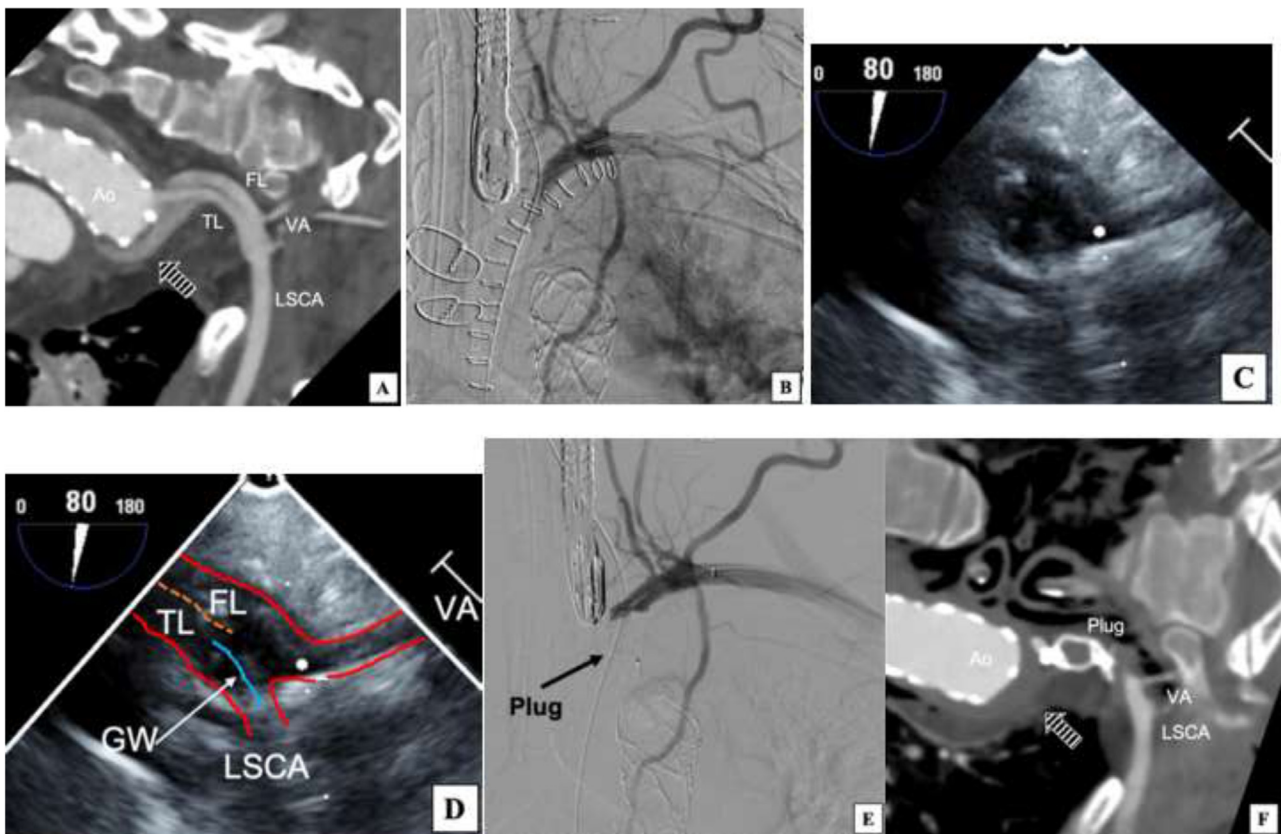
(A) Postoperative contrast-enhanced computed tomography showed retrograde blood flow around the frozen elephant trunk (striped arrow) from the false lumen of the left subclavian artery. The communication between the true and false lumens was at the level of the origin of the vertebral artery. (B) Left brachial artery angiography. (C) and (D) Transesophageal echocardiogram showed the left subclavian artery and vertebral artery. The left subclavian artery contained a true and false lumen. The entry of the false lumen was at the vertebral artery origin. The red lines denote vascular walls. The blue line indicates the guidewire. The dotted orange line indicates the intimal flap. (E) Postoperative angiography showed the plug placed at the origin of the left subclavian artery. (F) Postoperative contrast-enhanced computed tomography showed disappearance of the false lumen in the original left subclavian artery. Retrograde flow was no longer present (striped arrow). Abbreviations: Ao, aorta; LSCA, left subclavian artery; VA, vertebral artery; GW, guidewire; TL, true lumen; FL, false lumen
